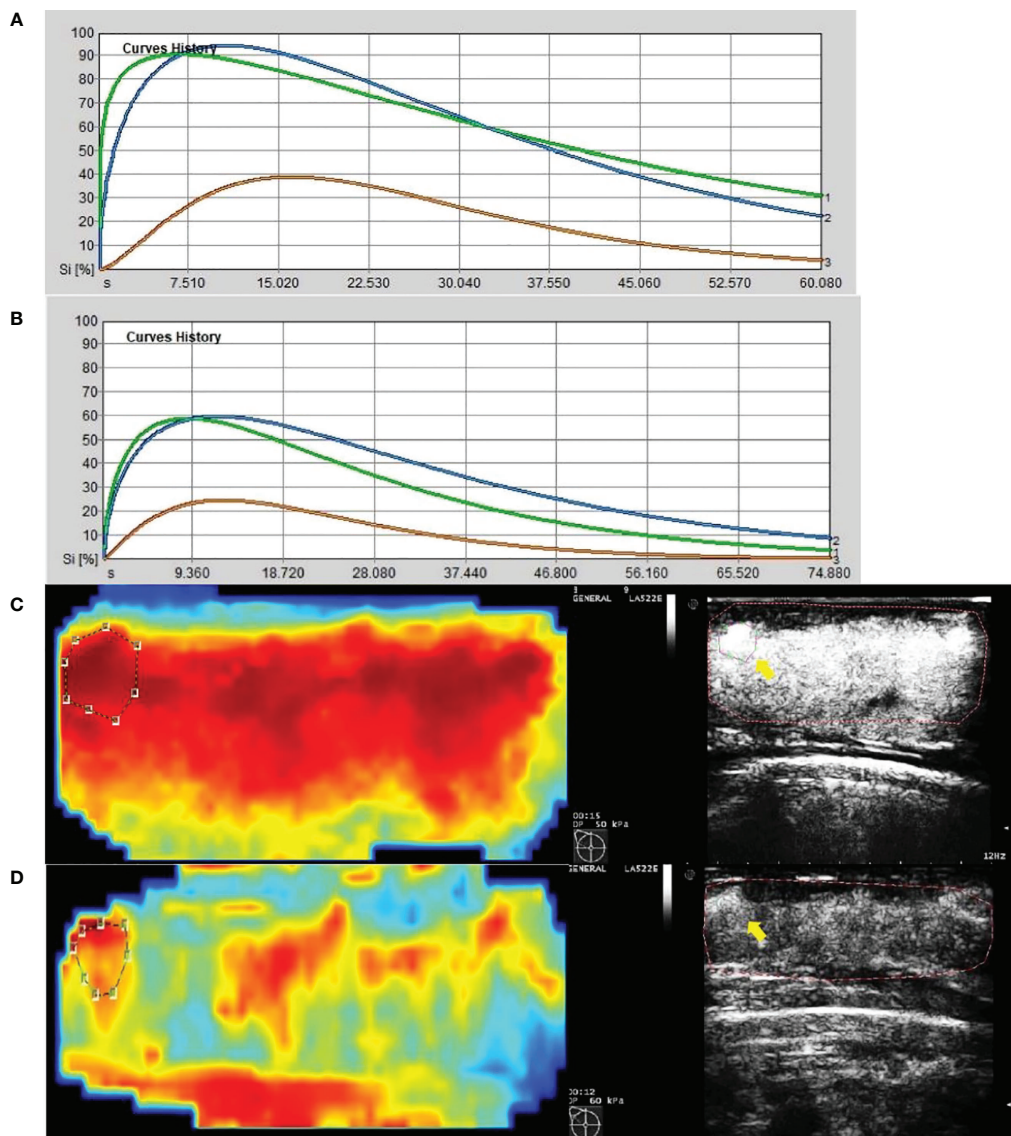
Images from a patient of response to NAC. (A) At baseline before NAC, contrast-enhanced ultrasound imaging showed a time-intensity curve generated according to regions of interest. The green line represents ROI 1(the greatest enhancement area in central region of tumor), the blue line represents ROI 2(the greatest enhancement area in edge of tumor), the yellow line represents normal breast tissue. (B) After the first cycle of NAC, both ROI 1 and ROI 2 declined significantly. (C) At baseline before NAC, the circle represents ROI 2, and the red area means rich blood supply; the right image was gray-scale which correspond to the left one, and the yellow arrow referred to ROI 2. (D) After the first cycle of NAC, the circle represents ROI 2, and the red area shrunk significantly; the right image was gray-scale which correspond to the left one, and the yellow arrow referred to ROI 2.
